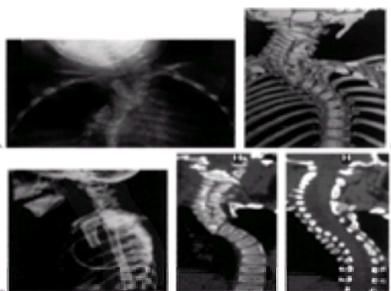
A: This 3-year-old patient presented with severe cervicothoracic scoliosis. The AP radiograph demonstrates a congenital etiology to the deformity; however, the details of the malformation are difficult to appreciate on the plain radiograph. B: A three-dimensional CT scan demonstrates much more clearly the anatomic deformities in the vertebral bodies. C: Frontal plane reformatted images are helpful in analyzing the size and number of hemivertebrae, as well as detecting unsegmented bars. The ability to obtain these images along a curved surface (produced with special software) is particularly useful in following the curvature of the spine in either the AP or lateral projections. Here the sagittal plane (lateral) curved scout film is seen. D: The anteroposterior reformatted images through the mid-portion of the vertebral bodies allows identification of the hemivertebrae and associated wedged vertebrae throughout the cervical and upper thoracic spine. E: An anteroposterior reformatted image, through the level of the pedicles, demonstrates two areas of an unsegmented bar in the concavity of the cervicothoracic deformity.
